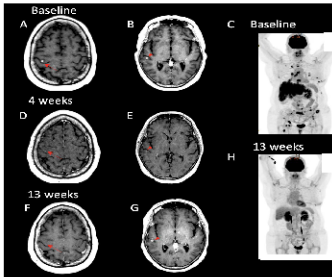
Radiographic example of a patient who achieved both systemic and intracranial tumor control.
